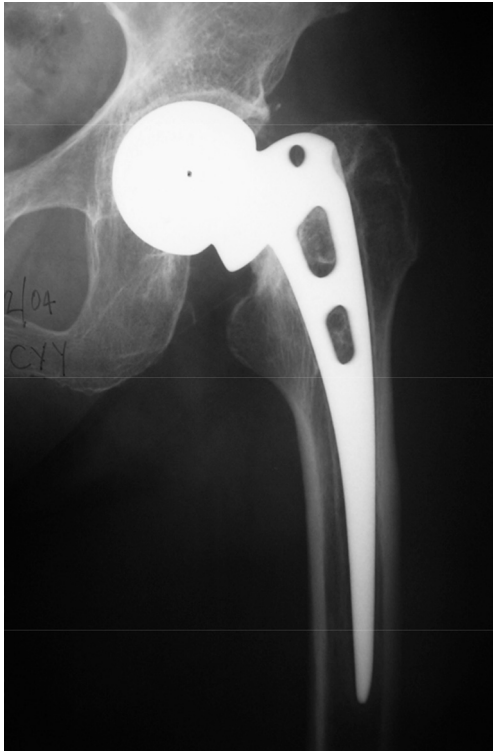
X-Ray of the Austin Moore prosthesis 8 years postoperation. A radio-opaque line along the medial side of the stem was noted, signifying probable loosening.
